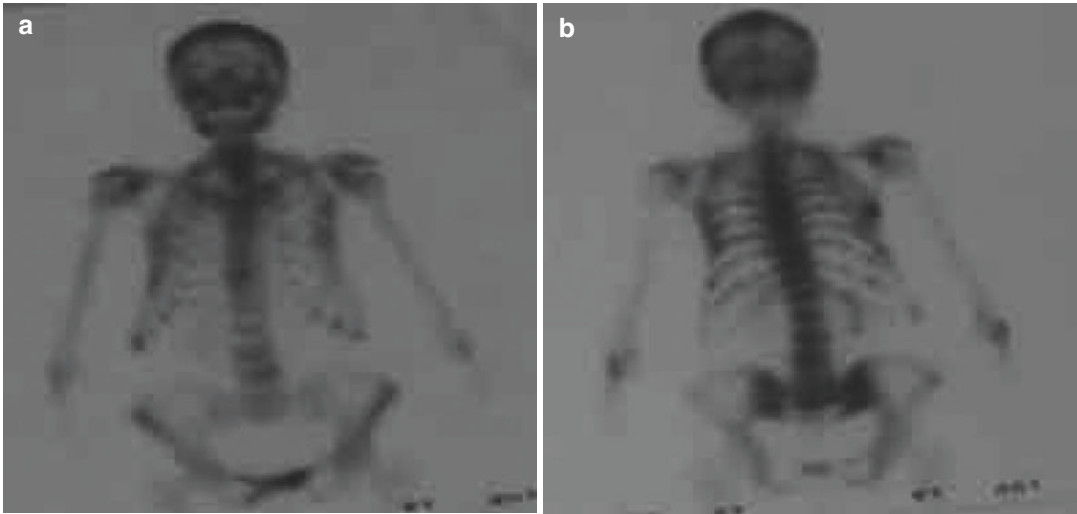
Case report 2. Skeletal scintigraphy: nonhomogeneous distribution of the radiopharmaceutical, minor lesions in the axial skeleton and ribs. It cannot be clearly decided whether it is a metastatic spread of minor deposits
